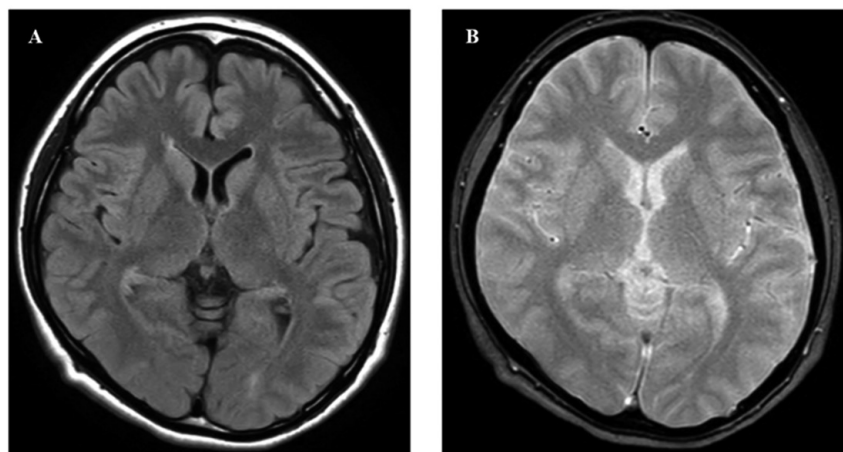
T1-weighted (A) and T2-weighted (B) MRI of the presented patient in few hours after minor sport-related head injury and manifestation of psychogenic non-epileptic seizures did not demonstrate any abnormal findings.
